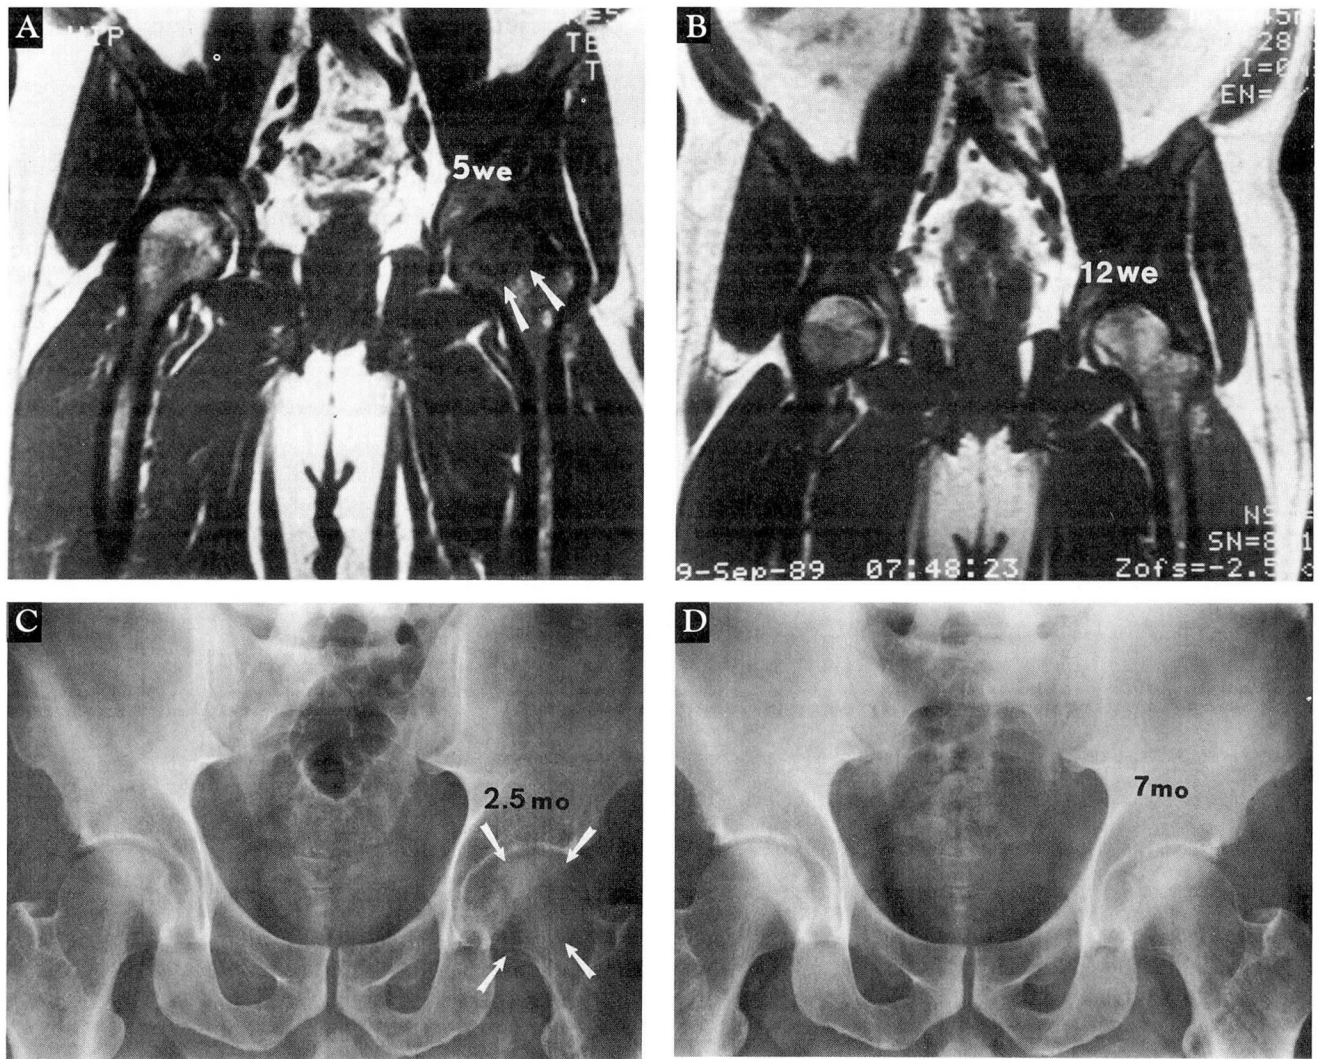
A 41-year-old man with transient osteoporosis of the left hip. At 5 weeks, coronal T1-weighted magnetic resonance image of the pelvis (A) shows decreased signal intensity in the left femoral head (arrows). Imaging at 12 weeks (B) shows complete remission of the abnormal signal. At 2.5 months, a frontal radiograph (C) shows transient osteoporosis of the left femoral head. A radiograph taken at 7 months (D), shows the osteoporosis almost completely resolved.
